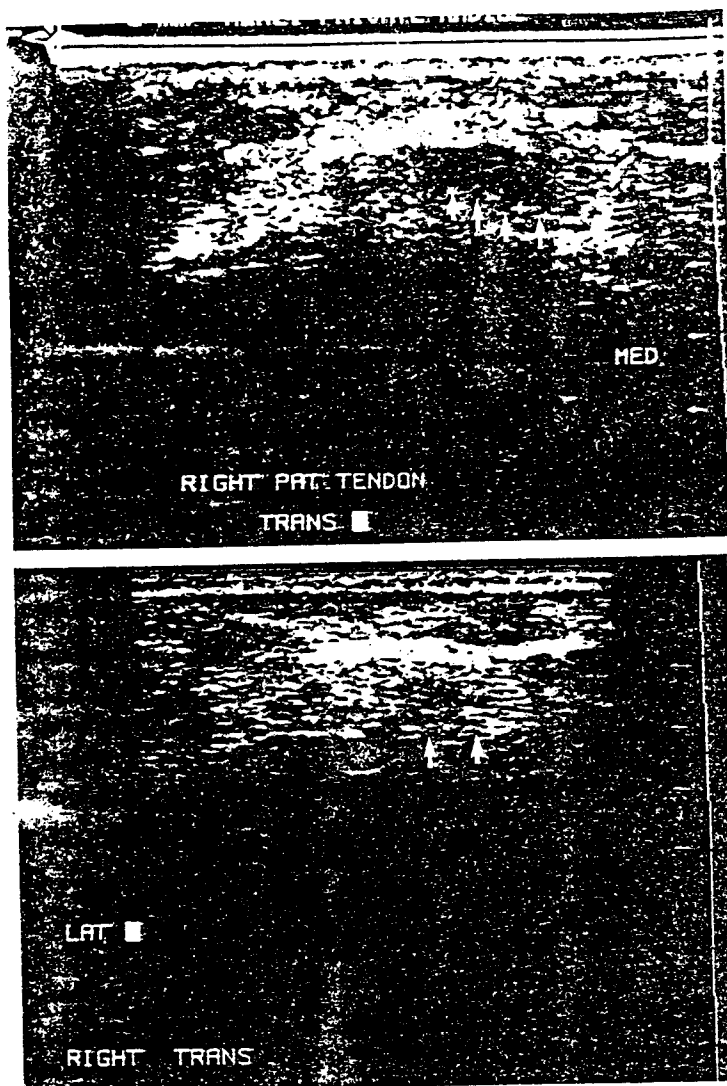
Axial sonographic studies conducted 22 months apart of a competitive 28-year-old basketball player with symptoms at baseline (A), but who was symptom free at follow-up (B), reveal essential resolution of the baseline hypoechoic sonographic area of the right patellar tendon. x-x, width 8.3 mm, +--+ height 3.3 mm at baseline.
